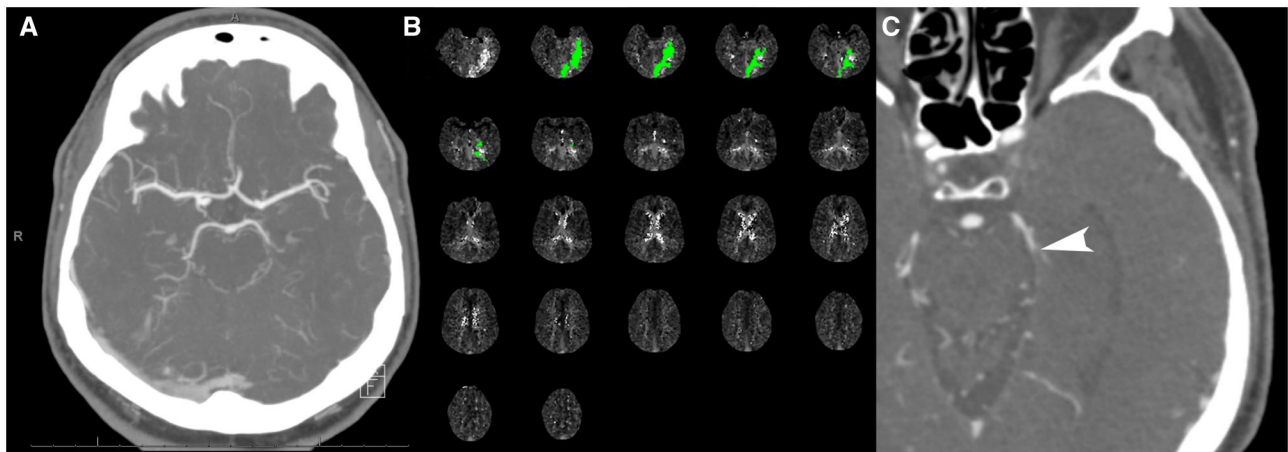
An elderly man presented to an outside hospital with a left middle cerebral artery syndrome. NCCT was normal, and the facility did not have the capability to perform CTA. IV tPA was administered, and the patient was transferred. Symptoms largely improved during transit. (A) CTA demonstrated no LVO. (B) TMax images from post-processed CTP showed delayed transit to the left posterior cerebral artery territory. (C) Further evaluation of the CTA identified occlusion of a P2 branch (arrowhead) of the left posterior cerebral artery.
